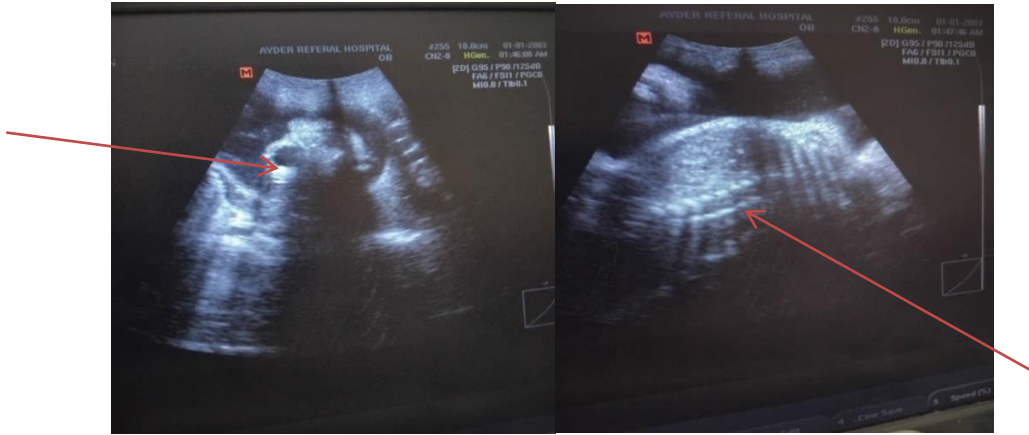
Ultrasonographically detected Anencephaly with normal spine scan of fetus in 35 years old primigravida pregnant woman at 32 weeks of gestation in ACSH, 2025.
